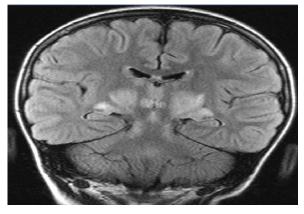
Coronal FLAIR image show symmetric increased signal intensity in the thalami.
